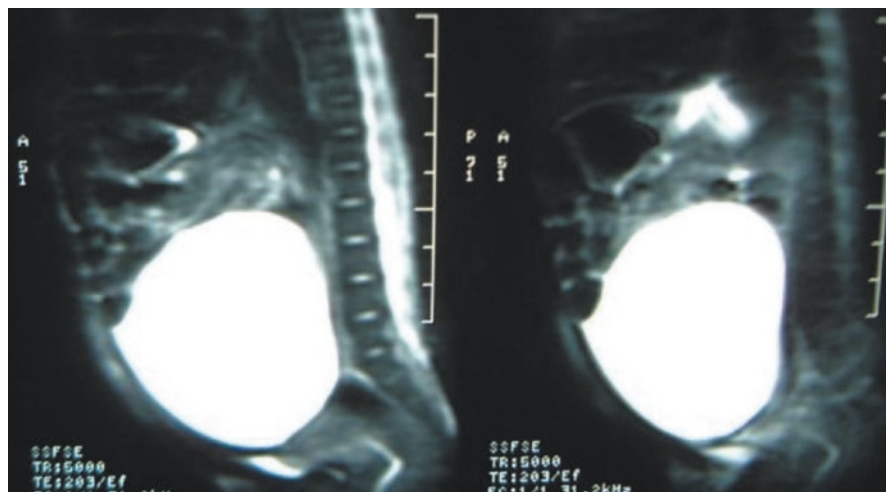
Abdominal and pelvic CT-scan showing a very large ovarian cyst in a neonate
